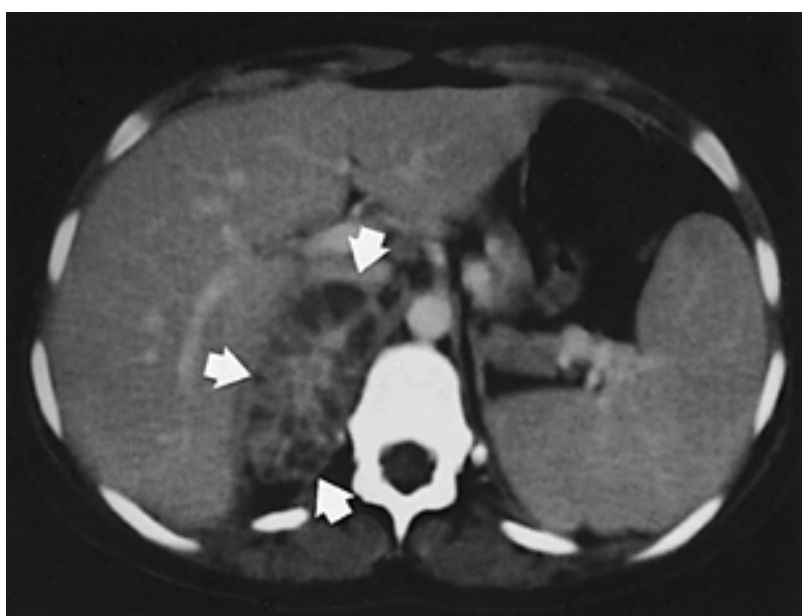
Perinephric abscess involving the right adrenal gland. Computed tomography scan. Large right pararenal mass (arrows) with multiple low-density areas within. At surgery, a large pararenal abscess with extensive involvement of the right adrenal was found.
